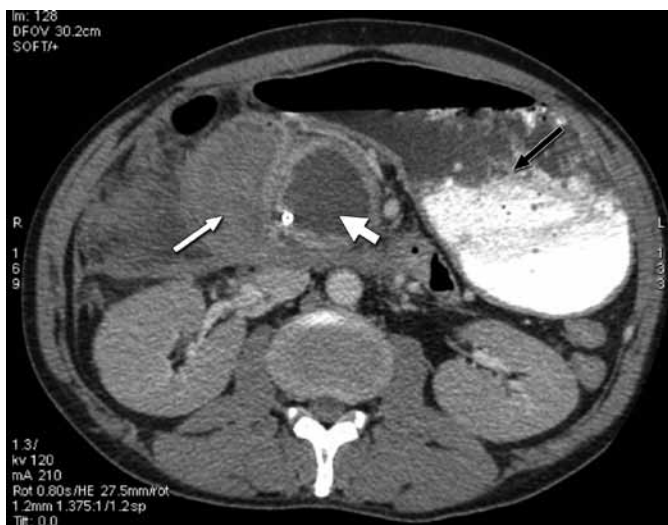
Axial CT image of the abdomen demonstrating a large sausage shaped duodenum with intramural hematoma (thin white arrow) with pseudo cyst in pancreas (short, thick white arrow). The black arrow represents stomach filled with contrast media.
